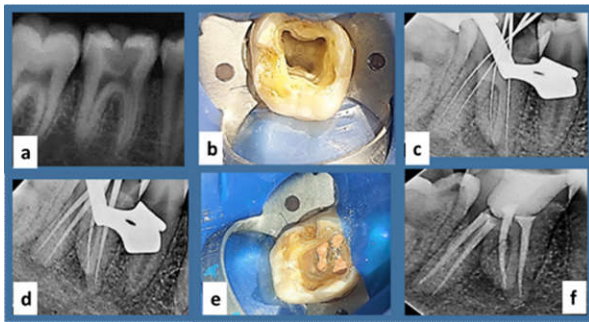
a) Pre op radiograph. b) Access opening. c) Working length determination radiograph d) Master cone selection radiograph. e) Obturation clinical view. f) Pst obturation radiograph
